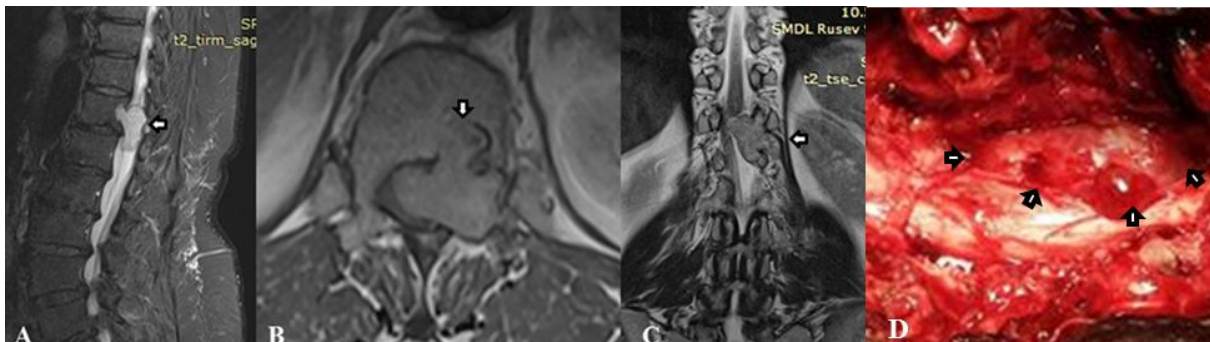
MRI image of extradural schwannoma: A/ sagittal view; B/ axial view; C/ coronal view and D/ intraoperative view
